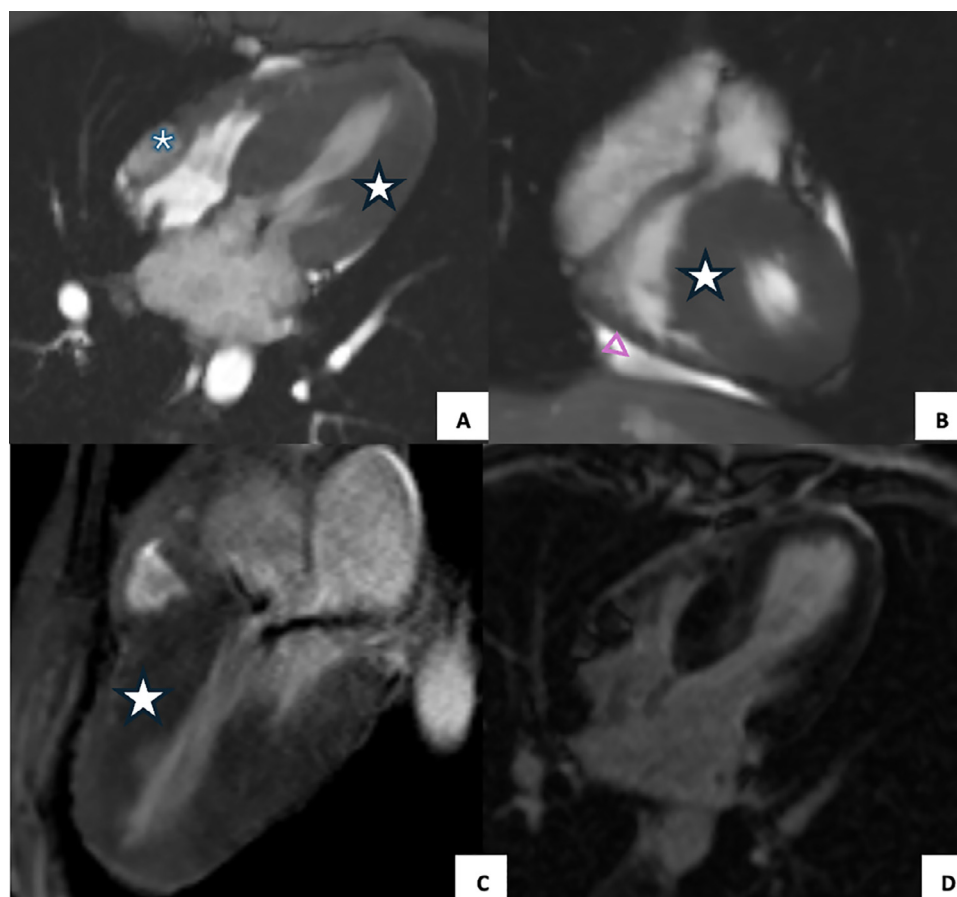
Cardiac MRI showing an intrapericardial mass on the right ventricular groove (A, *), mild pericardial effusion (B; triangle), systolic anterior motion (C) and no LGE in the LV (D).
